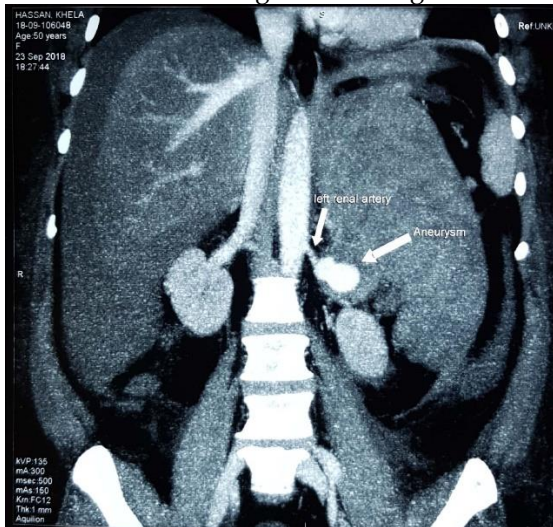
A coronal view of the CT - scan abdomen shows the left renal artery with the extravasation of the contrast and the presence of the aneurysm.
